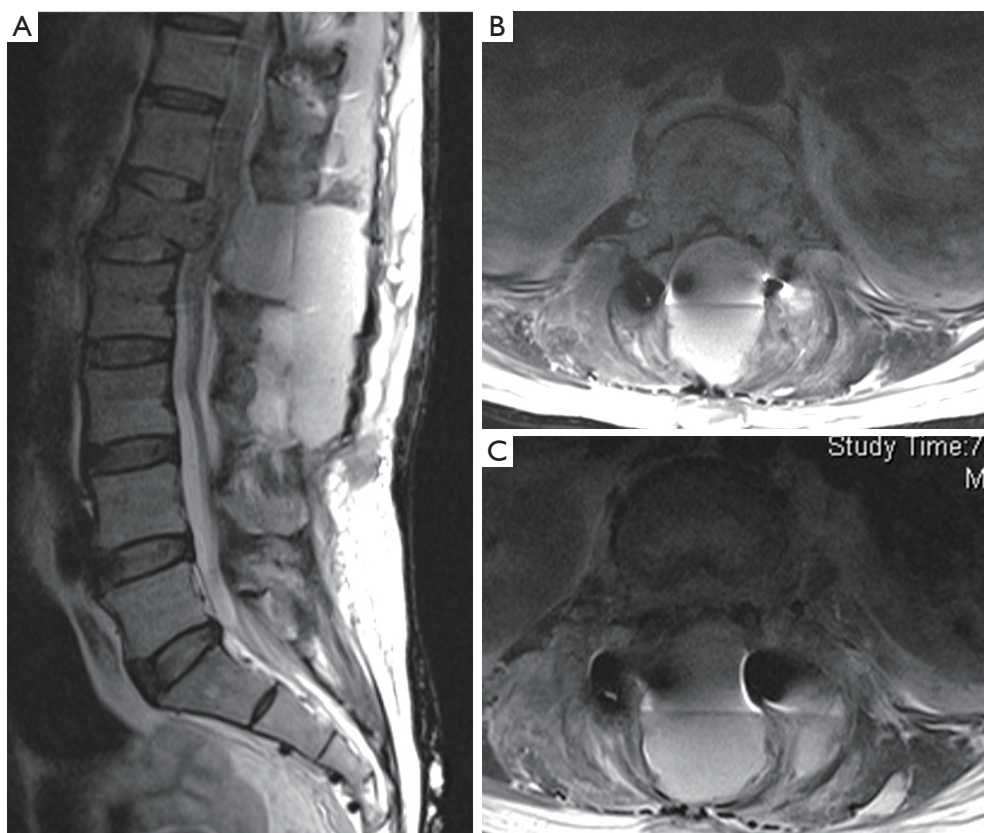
(A) Sagittal and (B,C) axial MRI images of the thoracolumbar spine showing the large epidural hematoma with severe cord compression in the lumbar spine.
